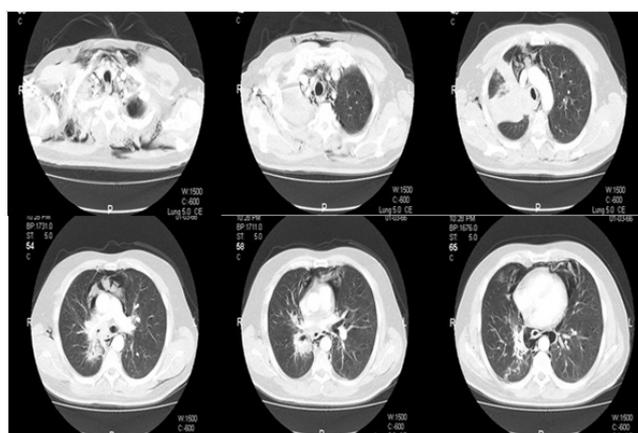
Thorax CT images of the patient on admission.
